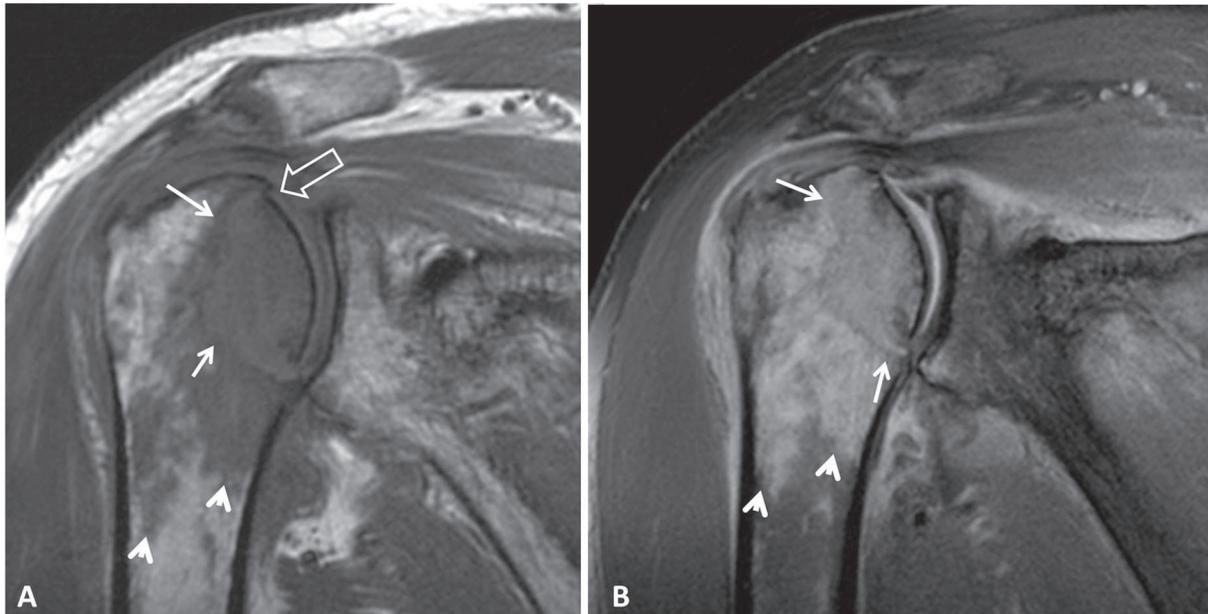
A 67-year-old male patient with pain of the right shoulder over the last month. Oblique coronal T1w (A) and fat suppressed PDw (B) MR images showing the lymphomatous lesion (arrows), reactive bone marrow oedema (arrowheads) and articular collapse (open arrow).
